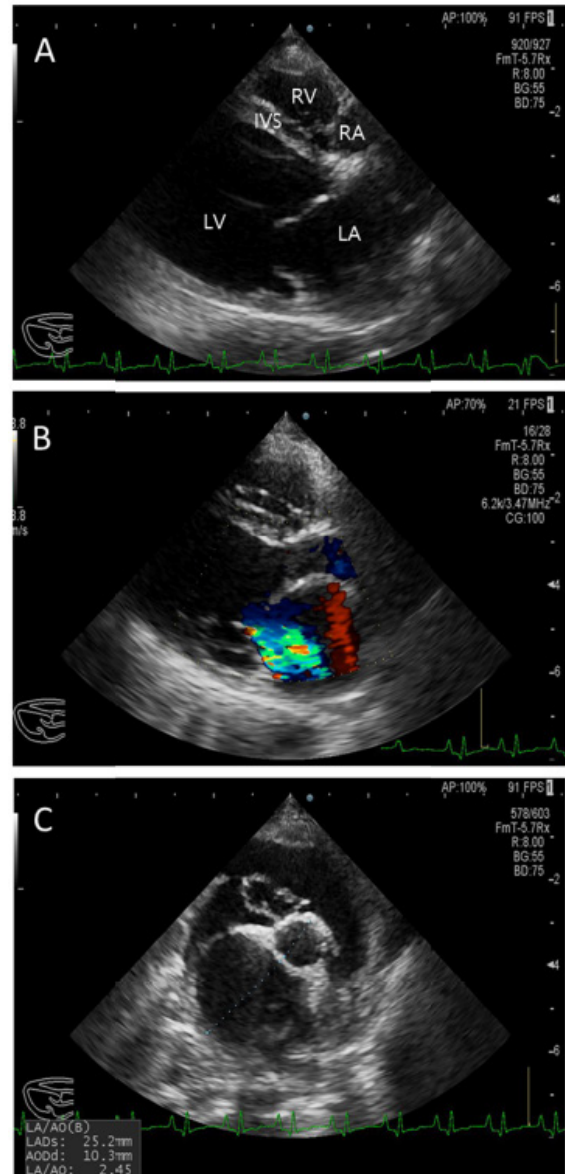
Echocardiography of the patient. Right parasternal long-axis (A, B) and short axis view (C) showing severe dilated left atrium (LA) and left ventricle (LV). Color-flow Doppler echocardiogram (B) showing eccentric mitral regurgitation during systole (arrow). The left atrial-aortic root ratio (LA/Ao) was 2.45 (C).
